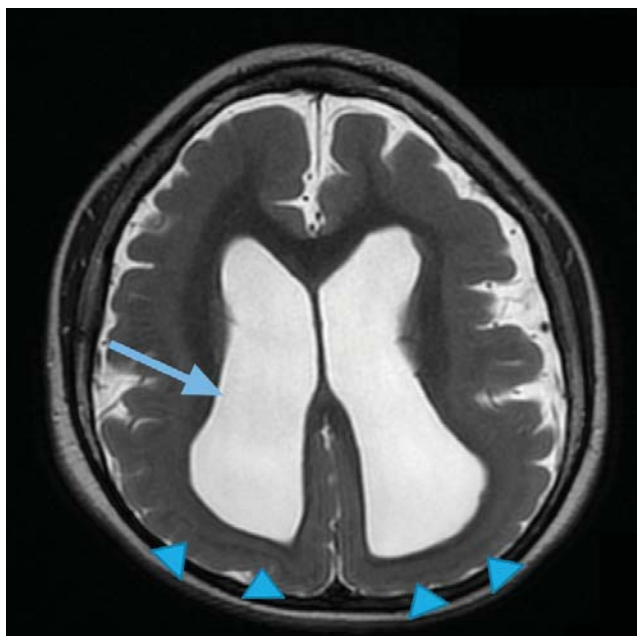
Cerebral MRI T2 Axial View. Ventriculomegaly (arrows). Disorganized gray matter located just beneath the cortex and separated from it by a thin band of white matter (triangles).
